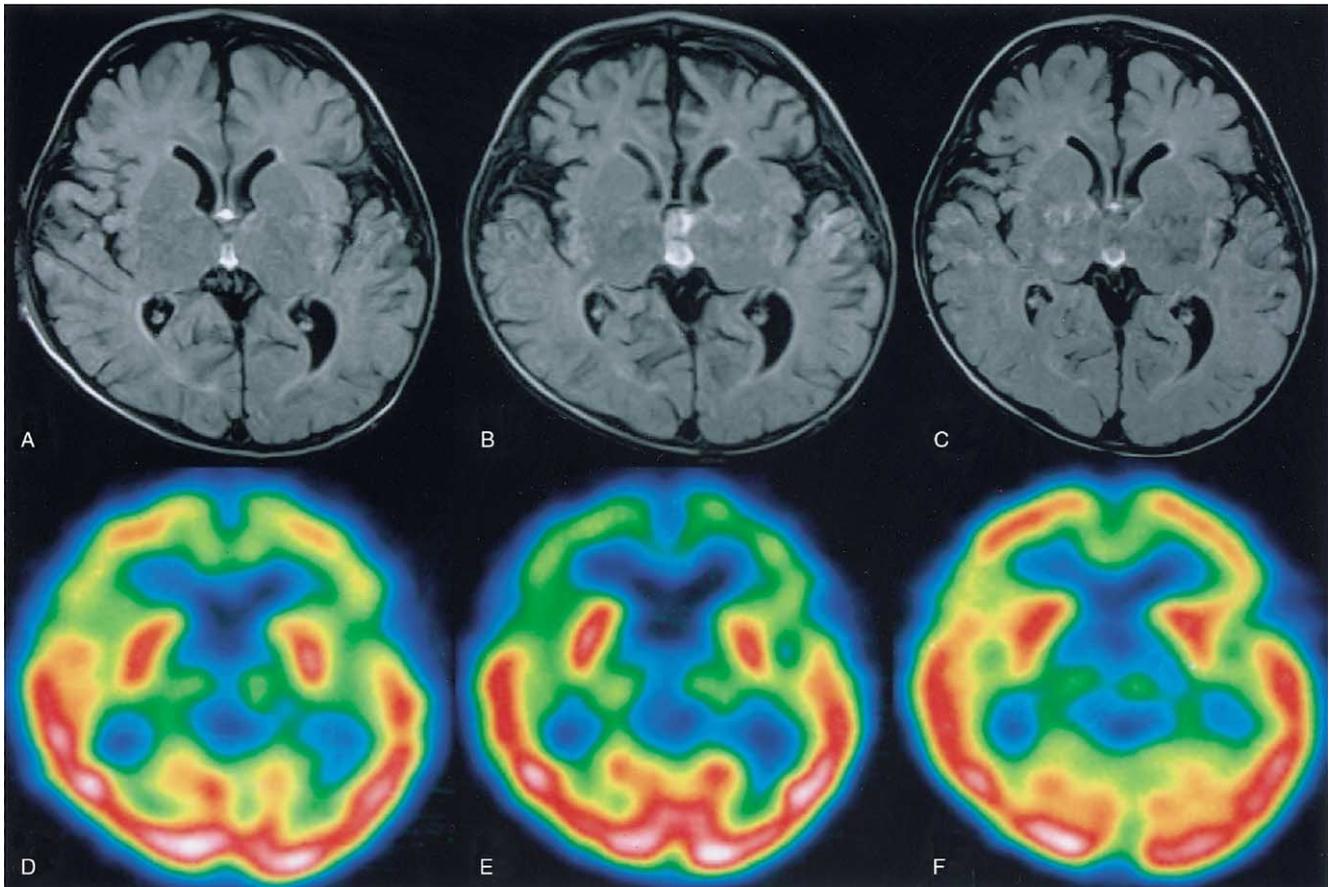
Serial magnetic resonance imaging (A, B, C: fluid-attenuated inversion recovery images, TR/TE/TI = 6744 ms/110 ms/1588 ms and single-photon emission computed tomography (D, E, F: ^{99m}Tc -ethyl cysteinate dimer) studies in Patient 1, which were performed at the tenth day (A, D), the seventh month (B, E), and the 21st month (C, F) from onset. Decreased cerebral perfusion in the frontal lobes was evident at the tenth day (D). Progressively decreased perfusion as well as atrophic change in the frontal lobes was observed at the seventh month. Improvement of perfusion and atrophy in the frontal lobes appeared at the 21st month.
